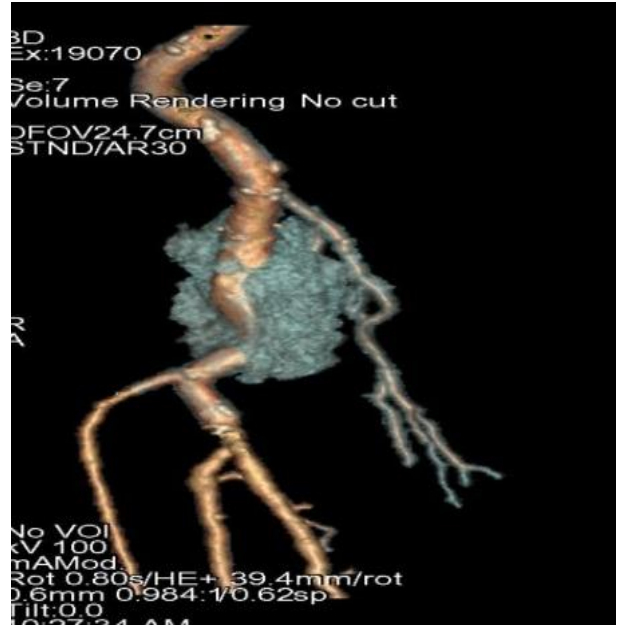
3D reconstruction of CT peripheral angiogram showing right popliteal artery aneurysms.
